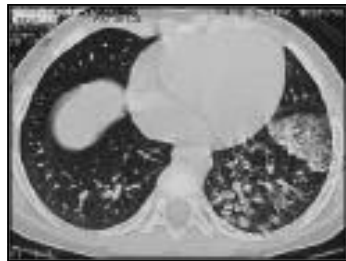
An high-resolution computed tomography of lower chest demonstrating high density lesions at left lower lobe.
